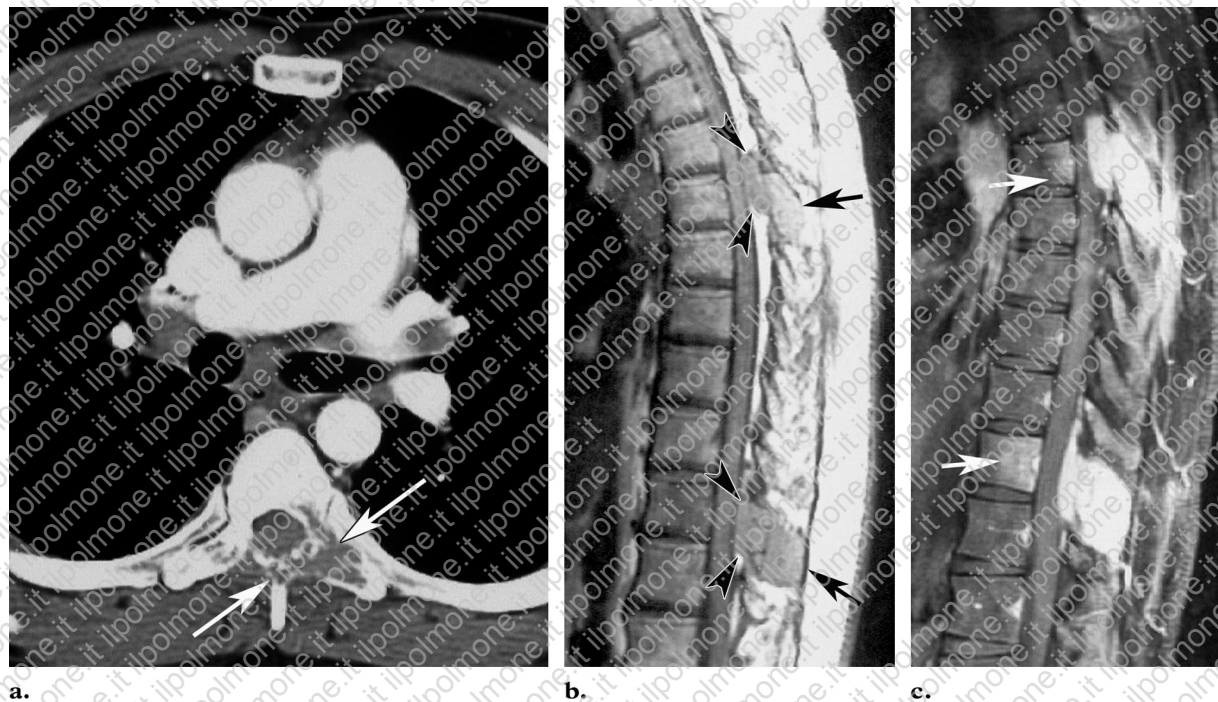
Bone sarcoidosis in the same patient as in Figure 2. (a) Contrast-enhanced CT scan demonstrates an osteolytic lesion in the posterior portion of the sixth thoracic vertebra (arrows). Bilateral hilar lymphadenopathy is also present. (b) Sagittal unenhanced T1-weighted MR image demonstrates multiple lesions in the posterior portion of the thoracic vertebrae. The lesions extend into the epidural spaces (arrowheads) and adjacent soft tissue (arrows). (c) On a contrast-enhanced fat-suppressed T1-weighted MR image, the lesions display diffuse enhancement. The presence of enhancement in the vertebral bodies (arrows) suggests disease involvement.
